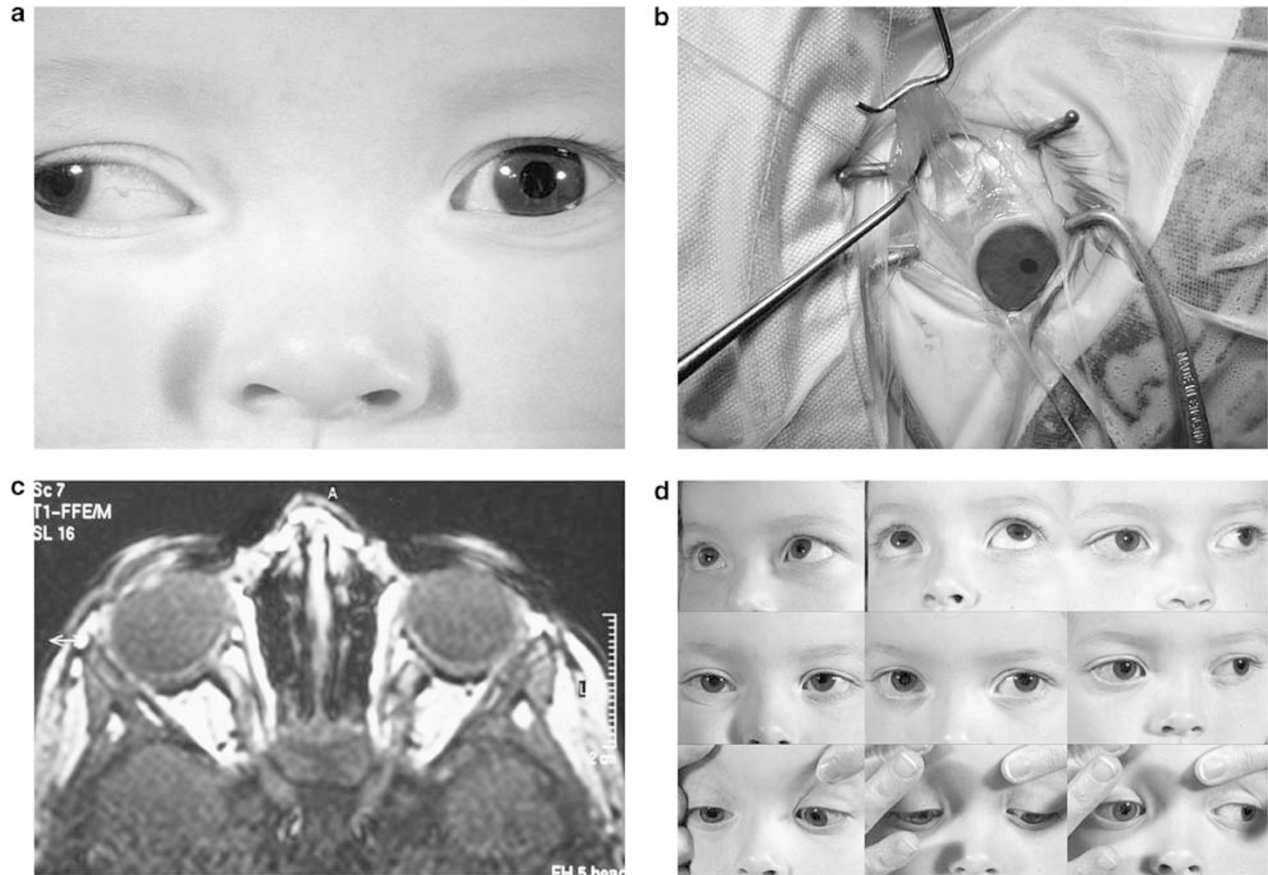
(a) Large-angle exotropia at presentation, (b) intraoperative view of left medial rectus muscle, (c) MRI showing thin medial rectus muscles, (d) 9-gaze template 2 months after strabismus surgery, showing improved adduction of left eye and residual effect of botulinum toxin in right lateral rectus muscle.
